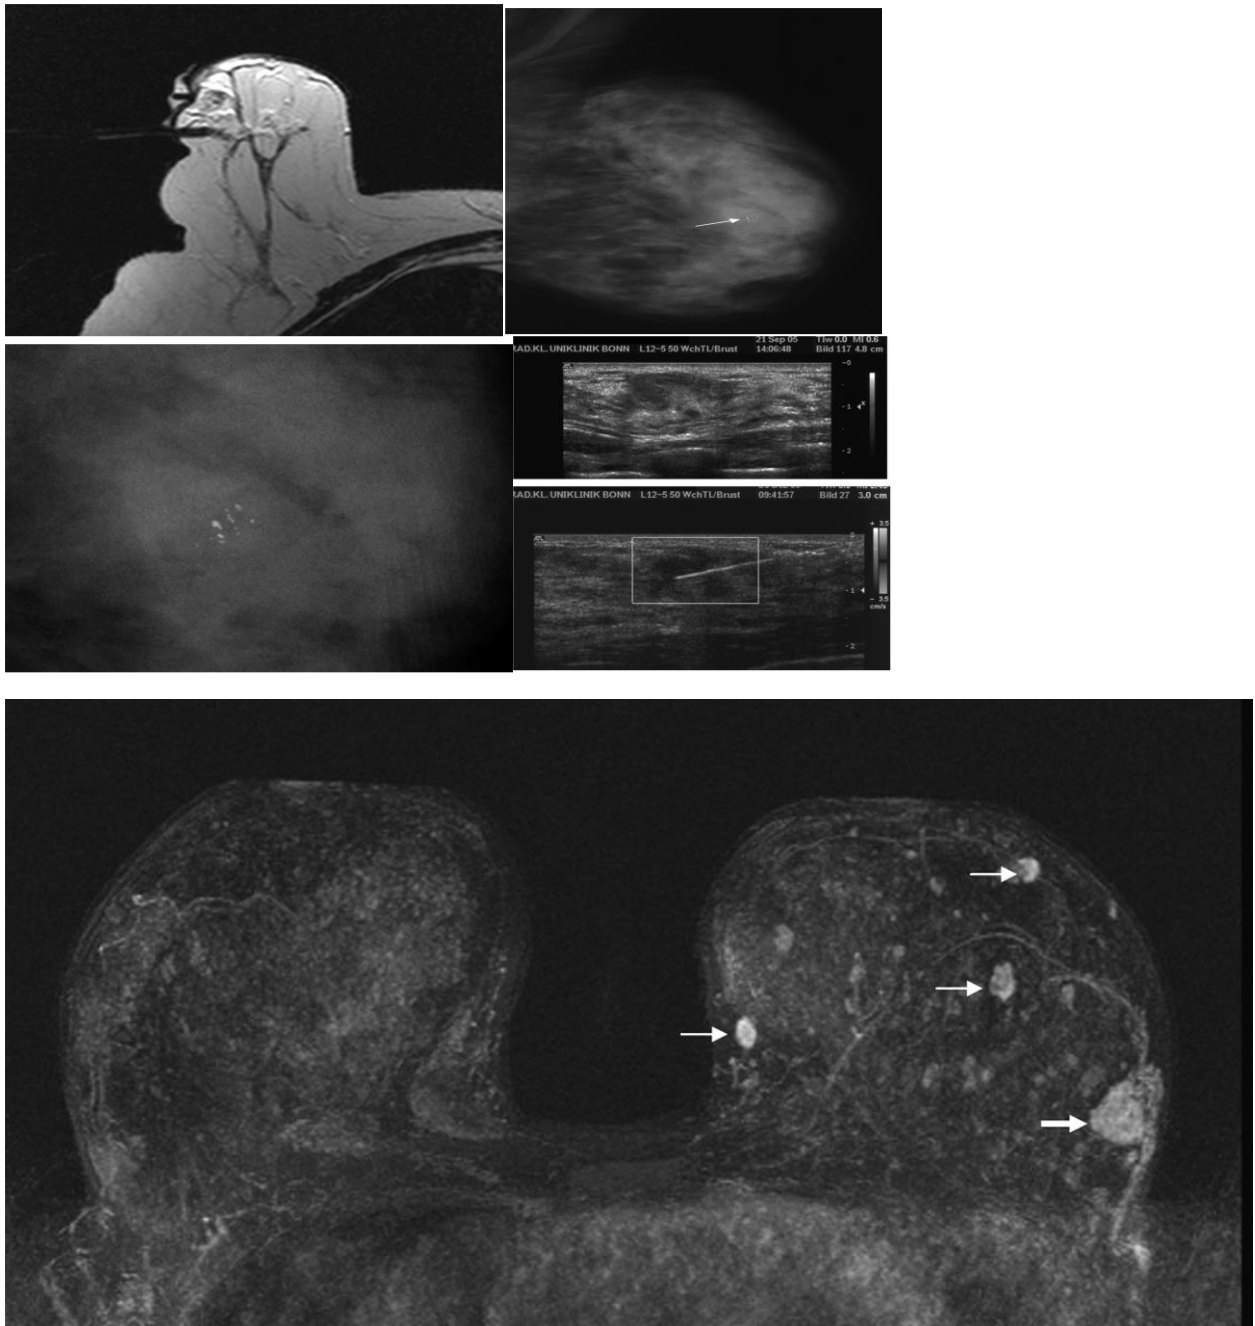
(b)After Mastectomy surgery MRI images on breast cancer [182].
